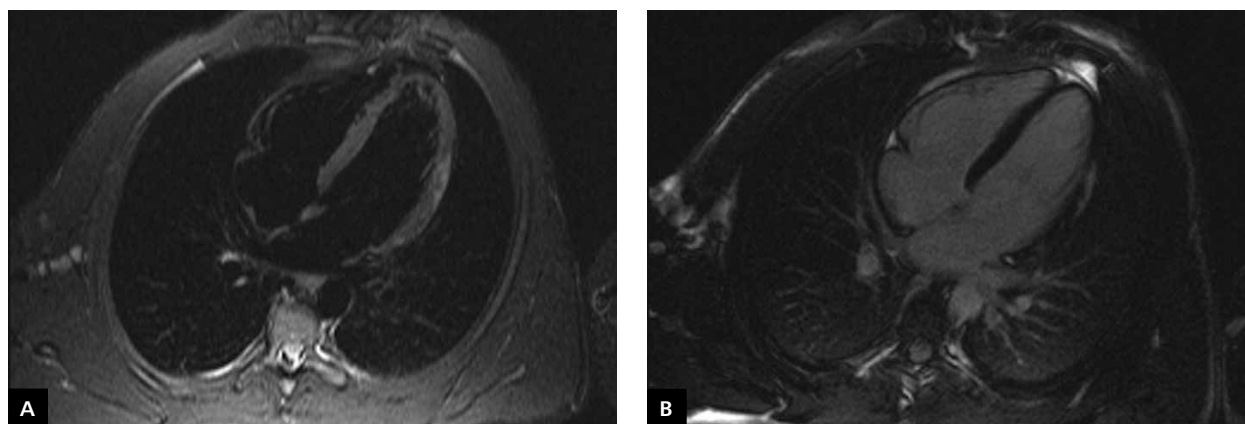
Cardiac magnetic resonance images in a patient with acute myocarditis; A. Four-chamber view. T2-weighted TIRM images. Myocardial oedema in the left ventricular lateral wall is seen (hyperintense areas); B. Four-chamber view. Late gadolinium enhancement images in the same patient. Areas of late gadolinium enhancement (areas of myocardial necrosis/fibrosis) corresponding to areas of myocardial oedema seen in Figure 2A
